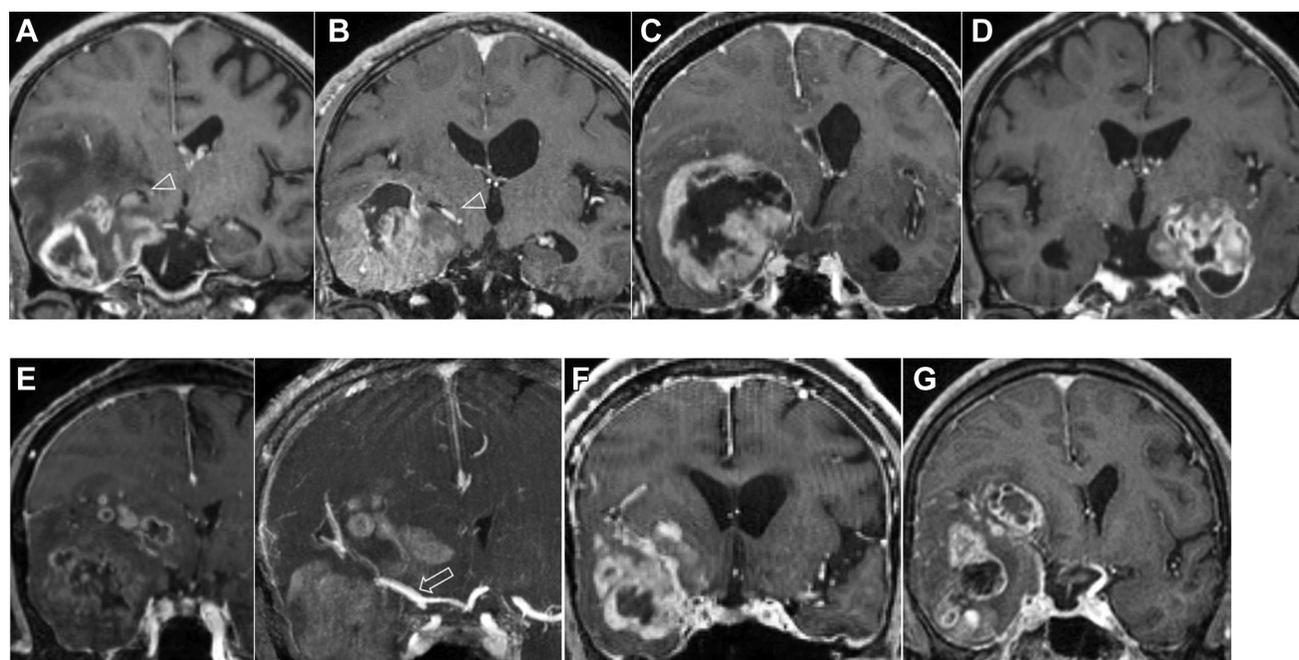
Preoperative coronal axial gadolinium-enhanced T1-weighted magnetic resonance imaging of 7 cases of medial temporal glioblastomas. A–G show Cases 1 to 7, respectively. A–D: Mimicking type causing upward displacement of the temporal horn (A and B, blank triangle).
